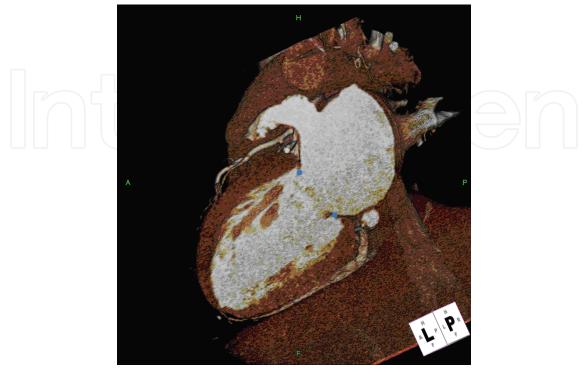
Cardiac CT reconstruction of left atrium and ventricle, connected via mitral valve (Image courtesy of Raquel del Valle – Lennox Hill Heart and Vascular Institute NY).
